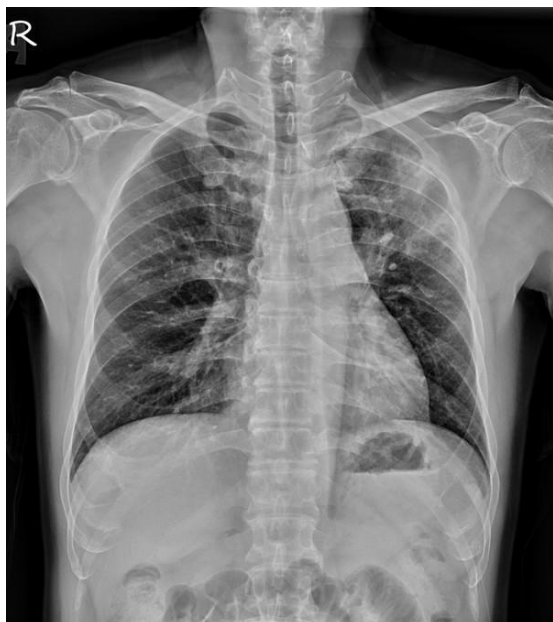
Pulmonary infiltrates in the left upper lobe presented in the chest plain film of this 58-year-old patient with non-productive cough for ten months, and shortness of breath with wheeze in the past one month.
